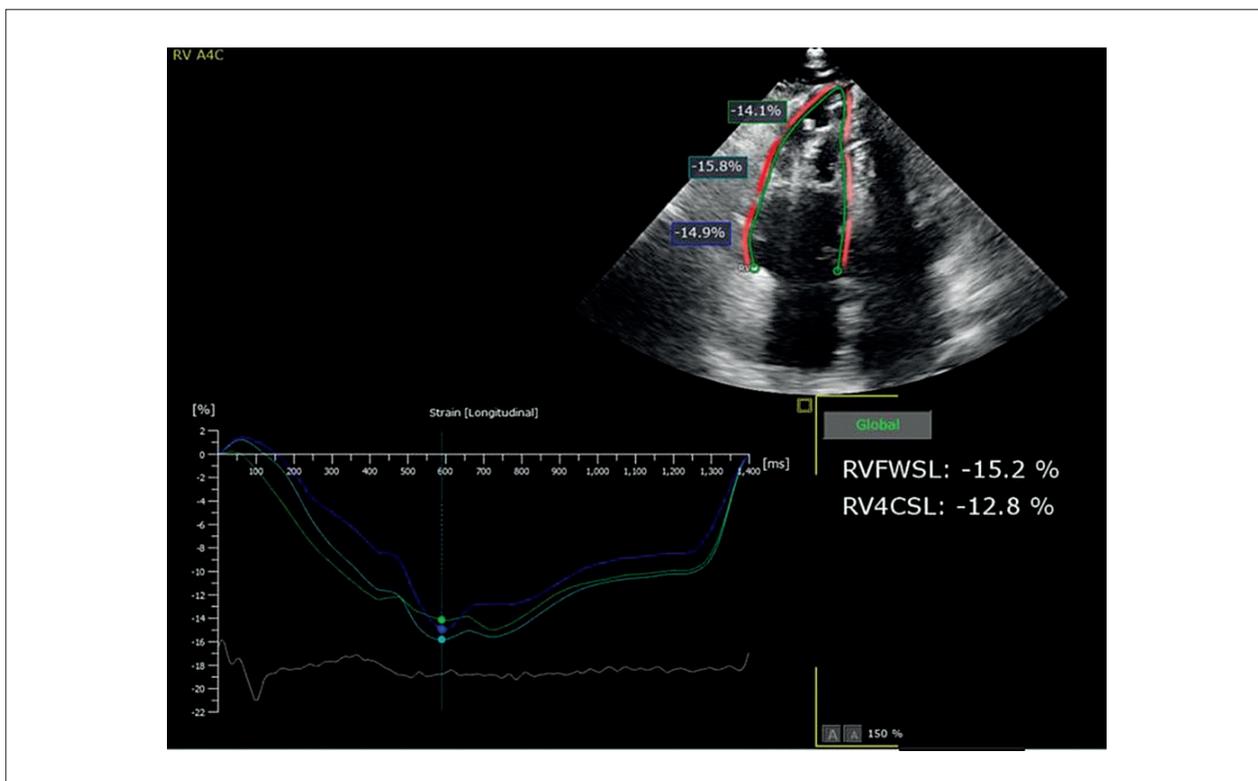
Assessment of the longitudinal strain of the right ventricle (RV), in the apical 4-chamber view focused on the RV, showing the results of the reduced longitudinal strain of the RV free wall and GLS of the RV: -15.2% and -12.8%, respectively.
